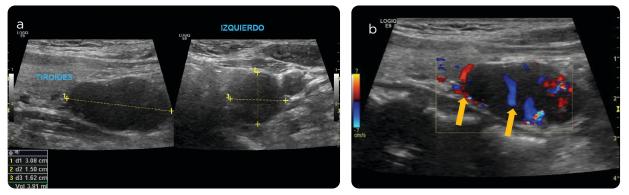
Neck ultrasound. a) In anatomical location of lower left parathyroid gland: oval, solid, hypoechoic, sharp-edged lesion. b) Color Doppler ultrasound: peripheral and central vascularity suggestive of malignancy (arrows).
